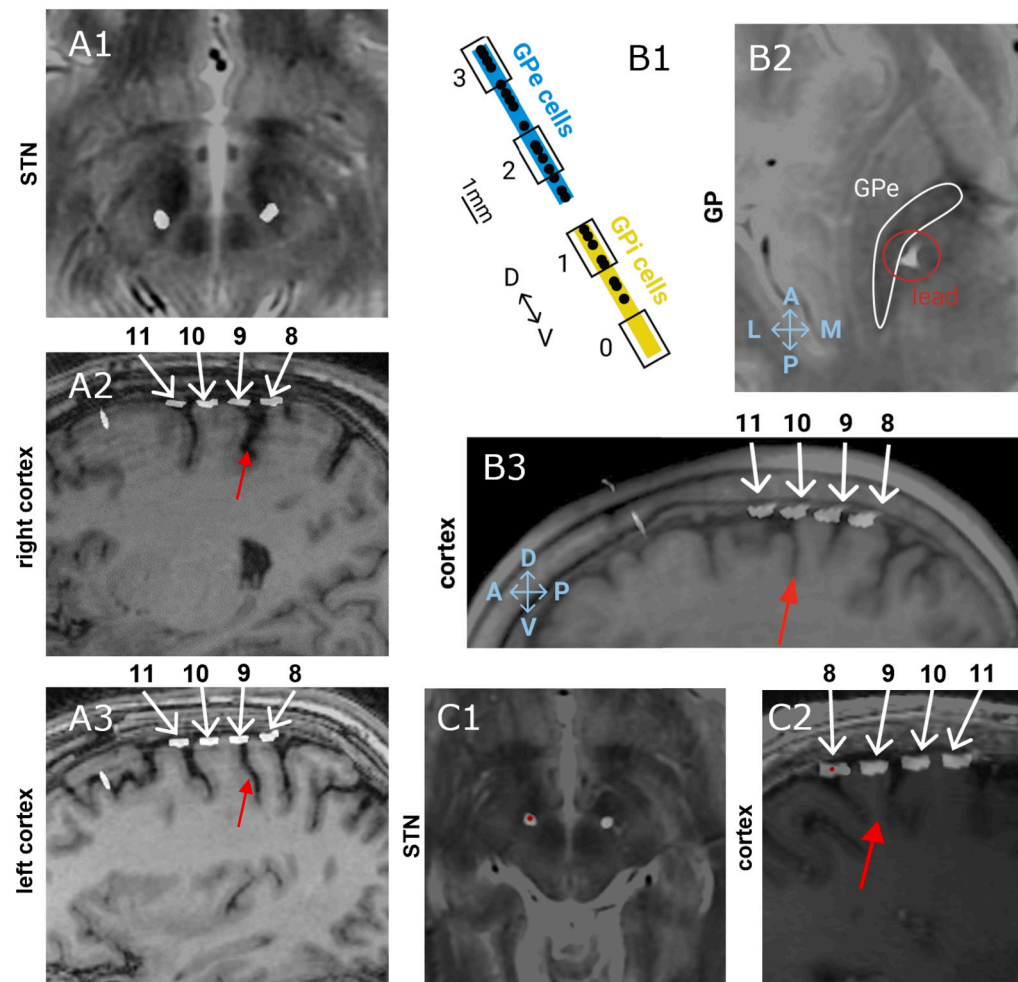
Contact localisation across the three subjects. The patients are presented as RCS02 (A1-3), RCS10 (B1-3) and RCS18 (C1 and 2). (A1-3, B2-3, C1-2) Localisation of contacts with a postoperative CT scan that is computationally fused with the preoperative planning MRI scan. (A1 and C1) subthalamic nucleus (STN) lead on a T2-weighted MRI scan. In C1, the red dot indicates the left STN lead. (A2-3, B3, C2) Quadripolar subdural paddle lead on sagittal T1-weighted MRI shows the relationship between the central sulcus (red arrow) and contacts (white numbered arrows). For RCS10 (A2-3) and RCS18 (C2), contacts 11 and 10 were both over the pre-central gyrus whereas contact 9 was on the post-central gyrus. RCS02 (B3) was implanted slightly more anteriorly and contacts 9 and 10 were on the pre-central gyrus and 11 on the superior frontal gyrus. (B1) globus pallidus (GP) contact localisation (black numbered rectangles) with respect to the boundaries of the internal globus pallidus (GPi) (yellow) and external globus pallidus (GPe) (blue) as defined by micro-electrode recording mapping of single-unit cells (black dots). (B2) GP lead on an axial T2-weighted MRI, which visualises the GP as regions of T2 hypointensity (GPe highlighted by a white contour).
